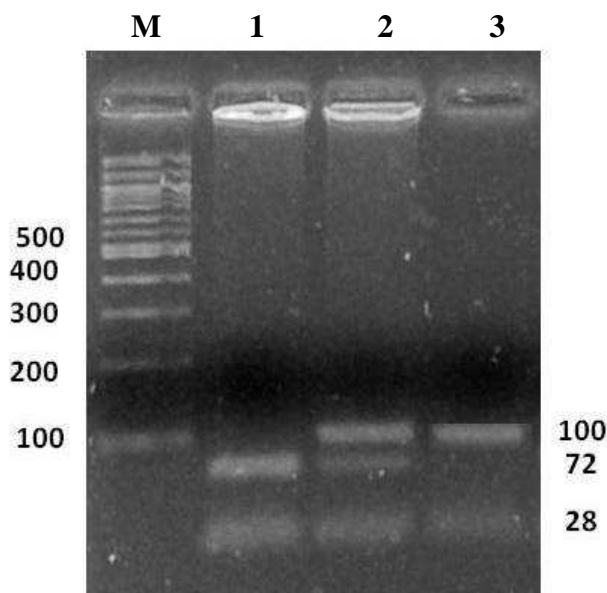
Gel de agarose 2,5% apresenta os genótipos do polimorfismo C677T do gene *MTHFR*. Coluna M: marcador de peso molecular 100 pb. Coluna 1: genótipo homozigoto selvagem CC. Colunas 2 e 3: genótipo heterozigoto CT. Coluna 4: genótipo homozigoto polimórfico TT.
